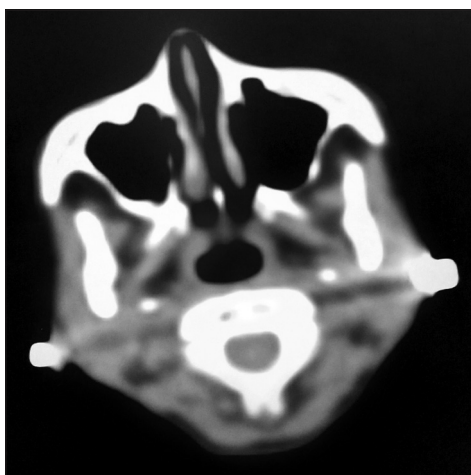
Postchemotherapy 18-fluorodeoxyglucose positron-emission computed tomography scan (fused image) showing complete metabolic resolution of the sphenoid lesion
